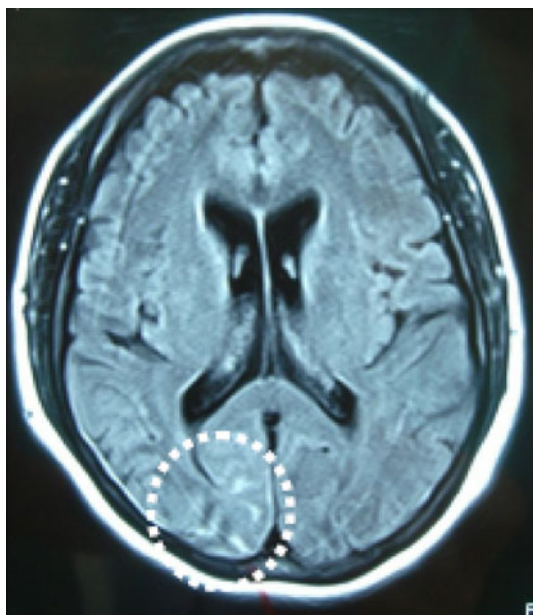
On POD 5, flair magnetic resonance imaging (MRI) demonstrated a high-intensity region (encircled) in the right posterior occipital lobe
